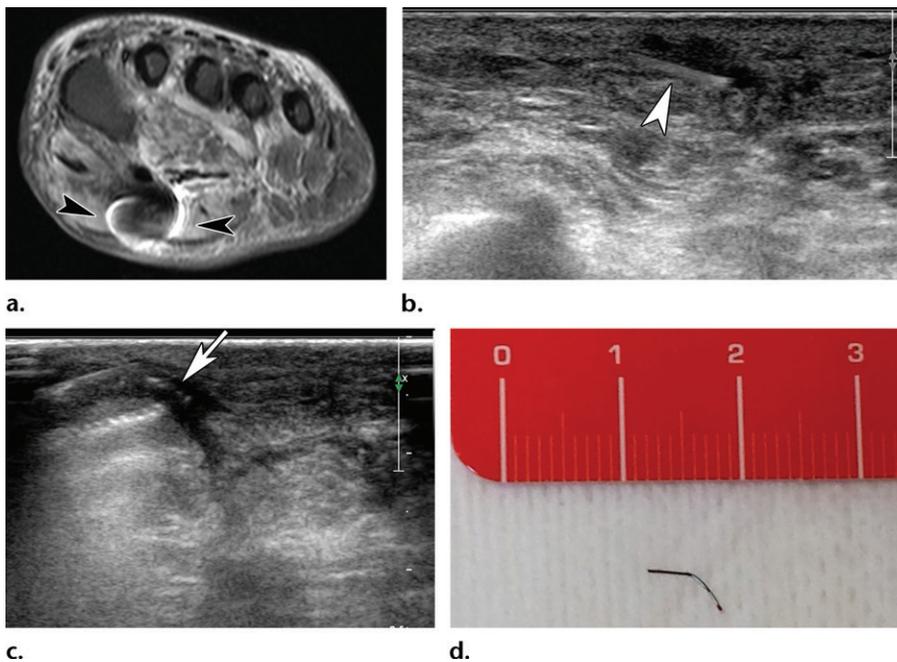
Foreign body in a 25-year-old man who reported pain in the left foot, which had worsened in recent weeks, and no previous trauma or injury. Physical examination results were normal. (a) Axial MR image shows a magnetic susceptibility artifact (arrowheads) on the sole of the foot. (b) US image obtained at the point of the observed artifact at MRI shows a small linear hyperechoic finding (arrowhead) surrounded by a hypoechoic halo. A foreign body was diagnosed. (c) US image obtained during the removal procedure shows the jaws of the Halsted mosquito forceps grasping the foreign body (arrow). (d) Photograph shows the removed foreign body, which was a thin metal splinter.
